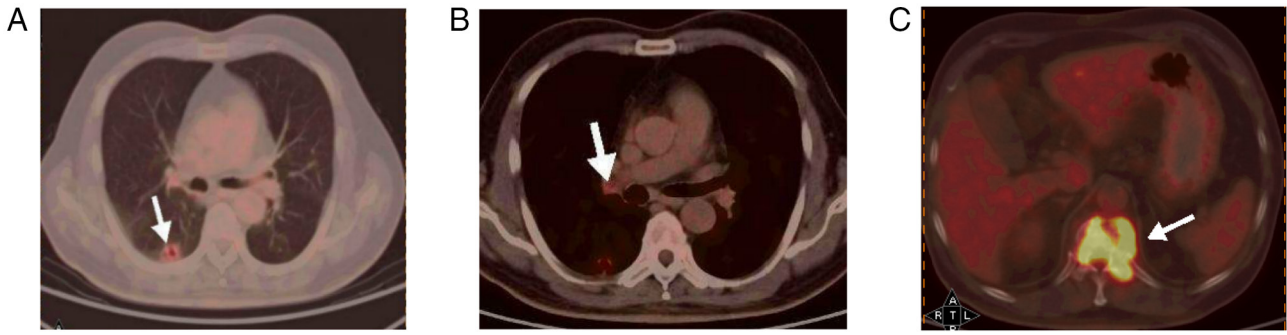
Positron emission tomography-computed tomography scan on patient admission. (A) The primary tumor in the right lower lobe of the lung (arrow). (B) Right hilar lymph node metastasis (arrow). (C) Vertebral metastasis (arrow).
